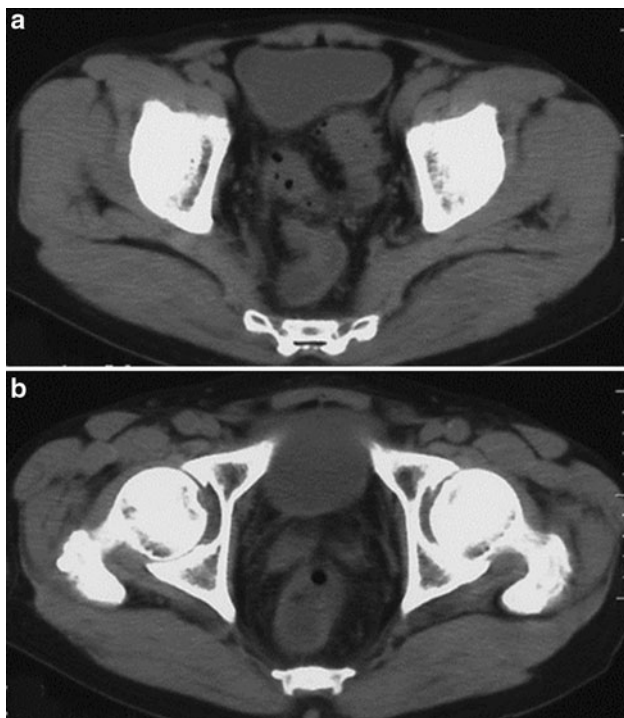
Abdominal CT scan. The post-procedure abdominal CT scan was negative for pneumoperitoneum or pericolic abscess
